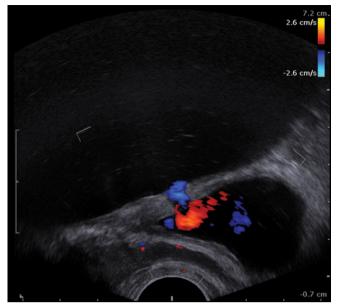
A color Doppler image shows a urine stream flowing into the urinary bladder through the neo-orifice. The examination was performed with a transrectal end-fire probe with the frequency of 12 MHz (ProFocus Ultraview, BK Medical, Denmark)
